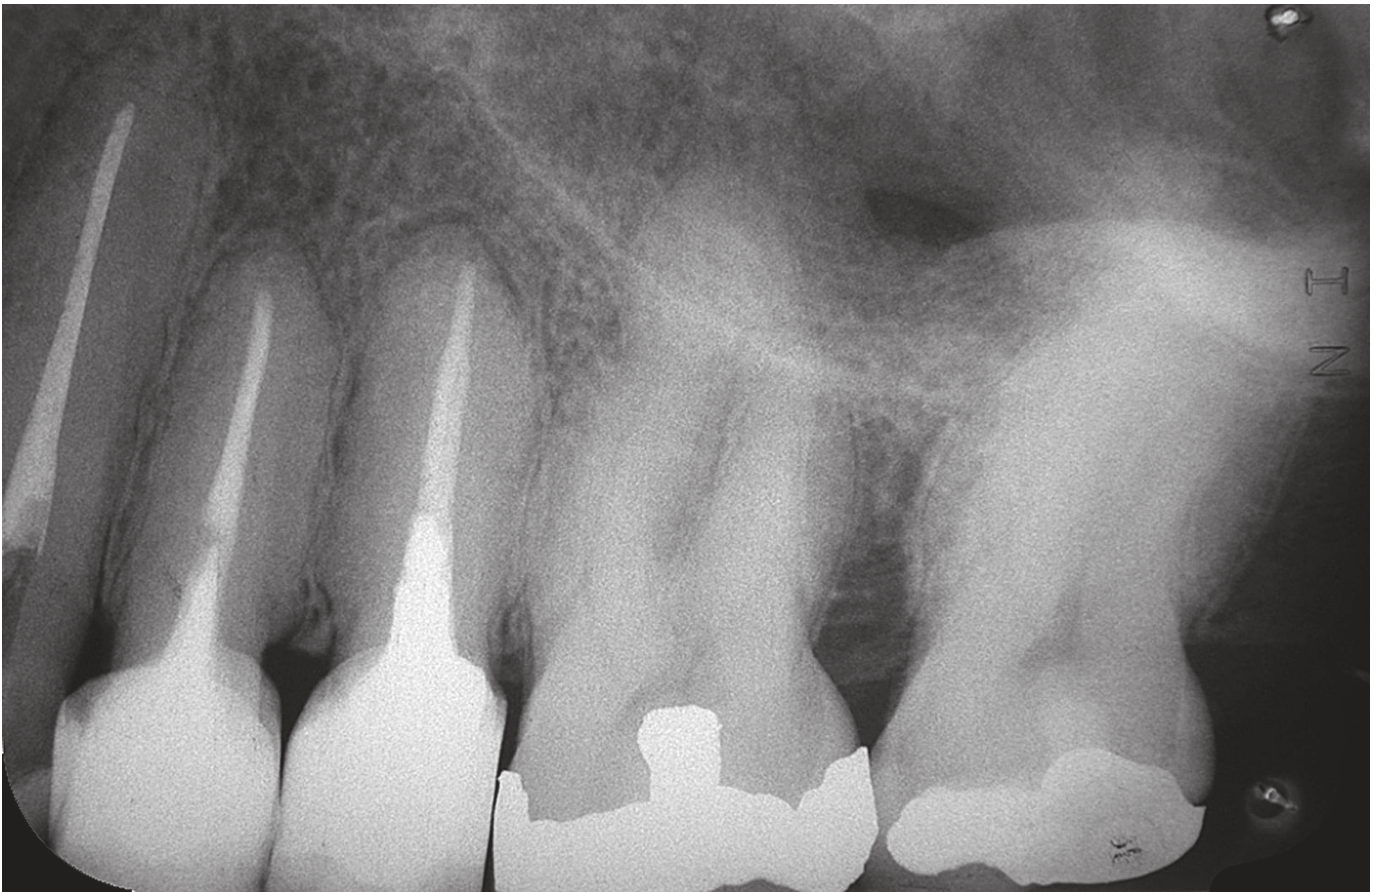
Periapical region of right upper teeth.
